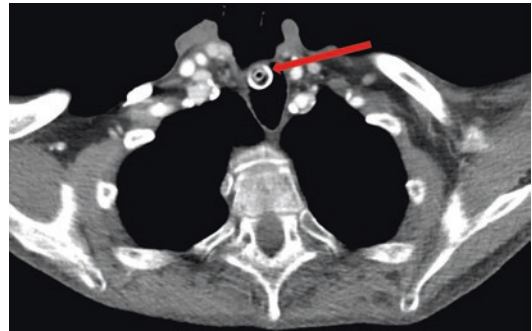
CT Scan of the typical location of a voice prosthesis (arrow) in the upper thorax. The esophagus behind the prosthesis is extended due to underpressure during inspiration!
